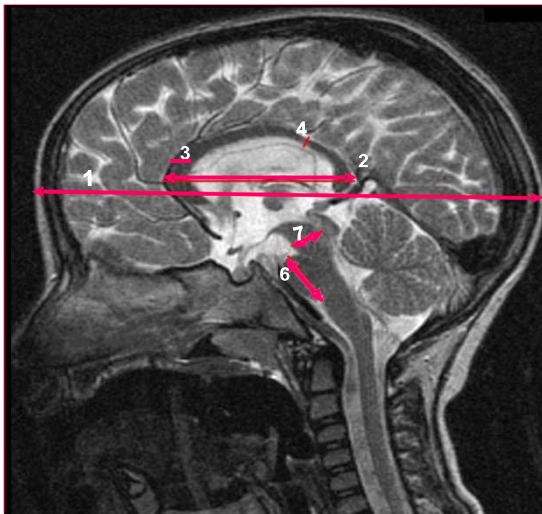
Midsagittal T2-weighted image. MRI-parameters:
